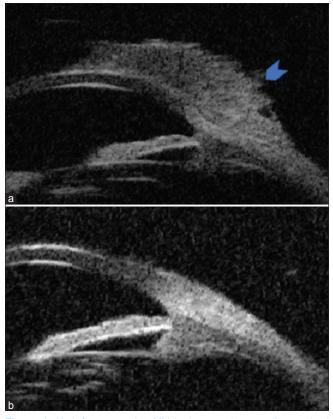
High-frequency (35 MHz) ultrasound image (longitudinal section) of giant ocular surface squamous neoplasm. Pretreatment (a) (blue arrow shows the epibulbar tumor) before treatment. (b) Posttopical chemotherapy showing resolution of the tumor along with absence of scleral or intraocular invasion (e.g., angle blunting or uveal thickening)
